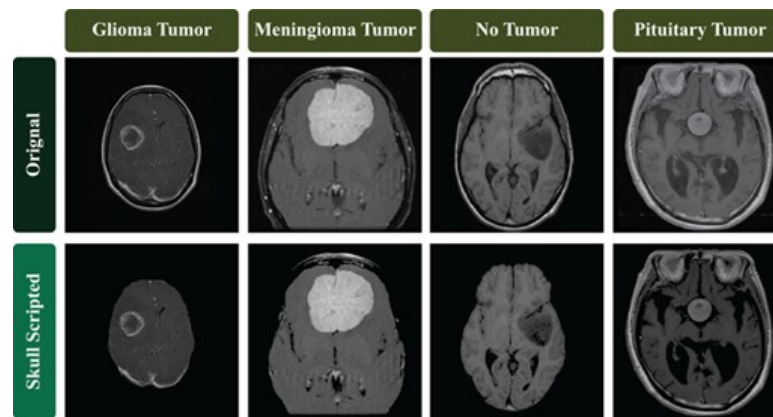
MRI images before and after skull stripping for brain tumor detection. Skull stripping removes non-brain tissues, enhancing focus on tumor regions.
